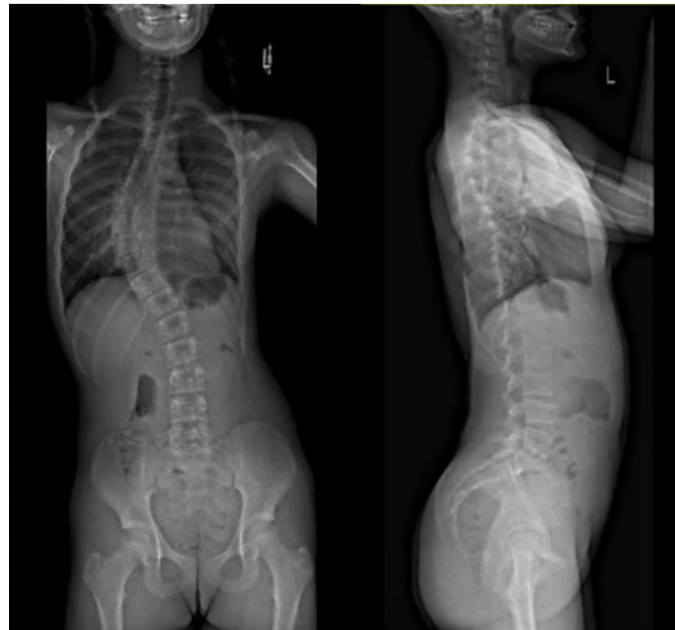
Posterior-anterior and lateral full-length spinal radiographs taken from an AIS patient at the Children's Hospital of Eastern Ontario
